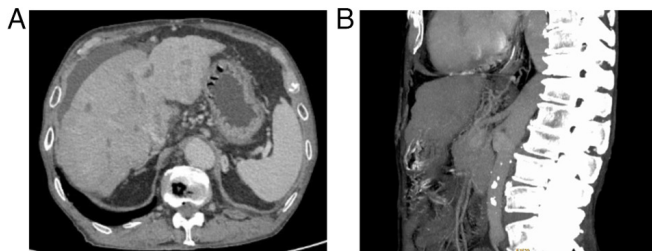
Computed tomography scans demonstrating (A) a nodular contour of the liver with capsular retraction, mild ascites, and (B) esophageal and gastric varices.
